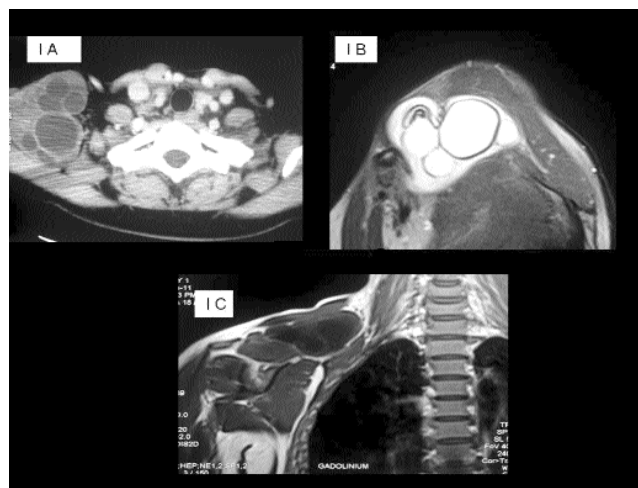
(a) Contrast enhanced CT scan, axial images, showing well defined multiloculated cystic lesion in the lower right neck infiltrating muscles. (b) T2 weighted MRI, axial image, showing well defined multiloculated cystic lesion consistent with diagnosis of hydatid cyst. (c) T1 weighted MRI, coronal image showing multiloculated cyst lower part of the neck.
